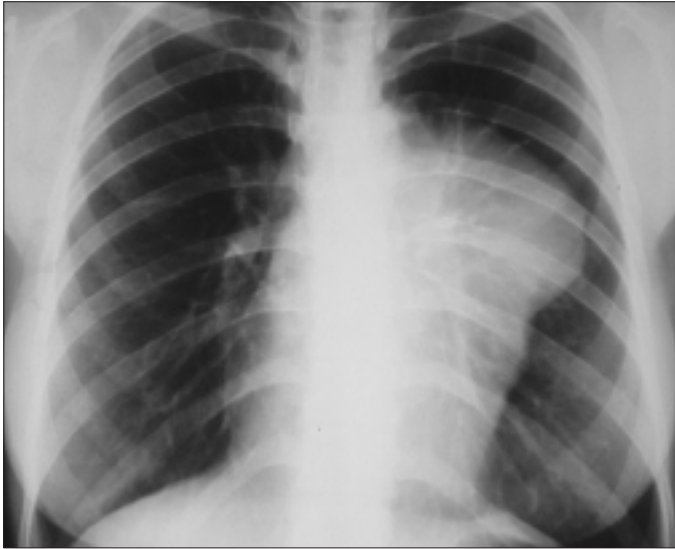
Chest radiography of the case before operation
